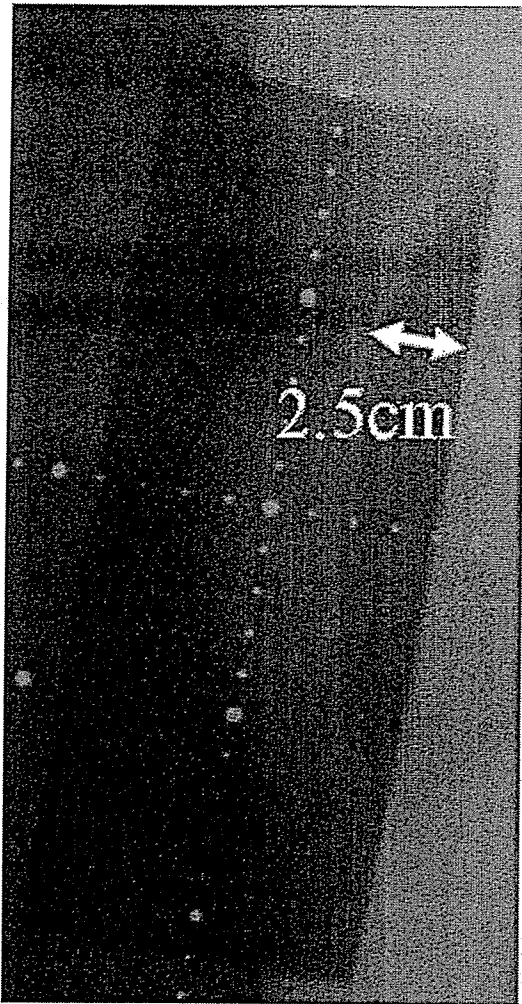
Linacography. Whole-breast irradiation was given with 6-MV X-rays, using a tangential field. The size was 22.0 cm by 8.0 cm, and the central lung distance was 2.5 cm
